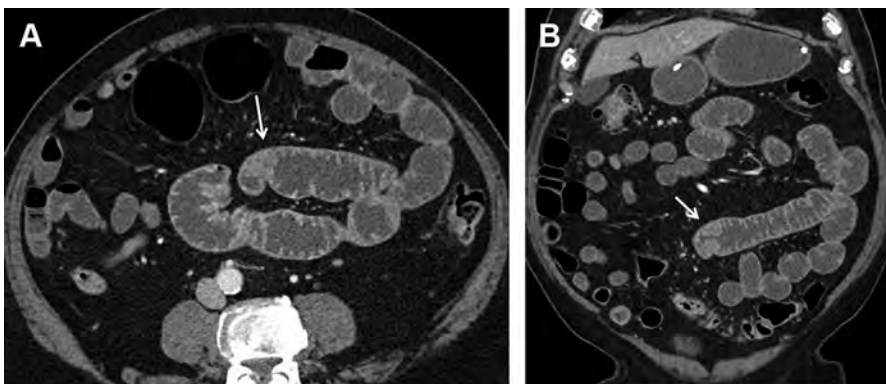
Jejunal lymphoma. A 77-year-old man with history of occult GI bleeding. Capsule endoscopy suggested a possible small bowel mass. Axial (A) and coronal (B) images from a CT enteroclysis demonstrate a subtle mass (arrows) in the jejunum that was subsequently shown to be a lymphoma. Note the isodense appearance that potentially could have been missed with poor bowel distension with enterography.
